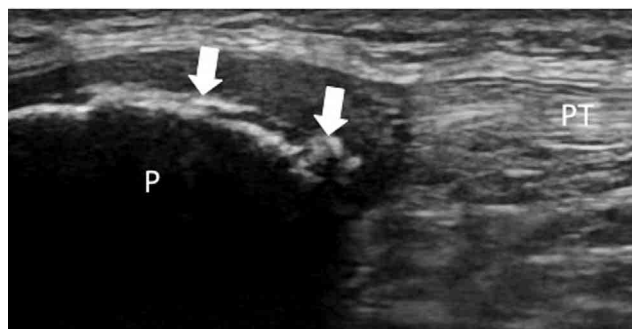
Sinding-Larsen-Johansson disease, longitudinal ultrasonographic image (10 year-old male, soccer). Fragmentation at the patellar distal pole (arrows). PT, patellar tendon, P, patella.
